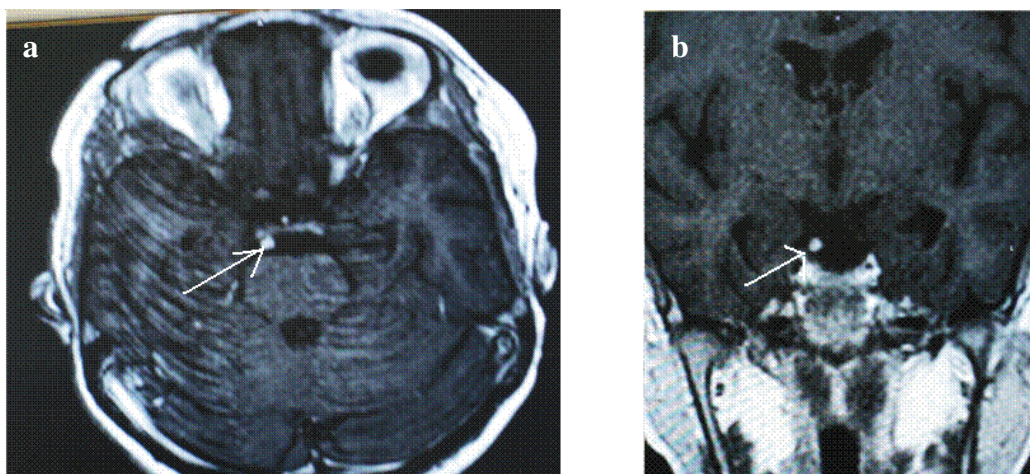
Brain MRI with contrast study showing a thickened, enhancing right oculomotor nerve.
